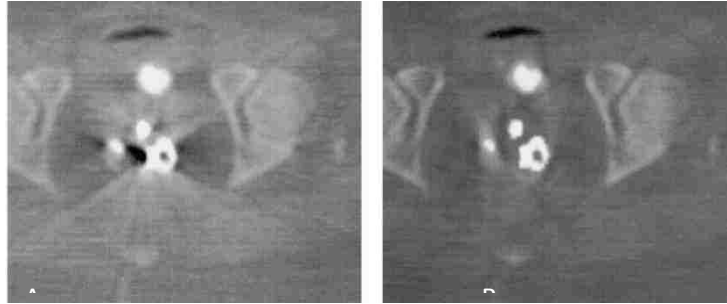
CT scan showing the top of the ovoids, tandem and contrast in the Foley catheter (A) before and (B) after CT projection-interpolation algorithm artifact reduction (Roeske, et al., 2003).
